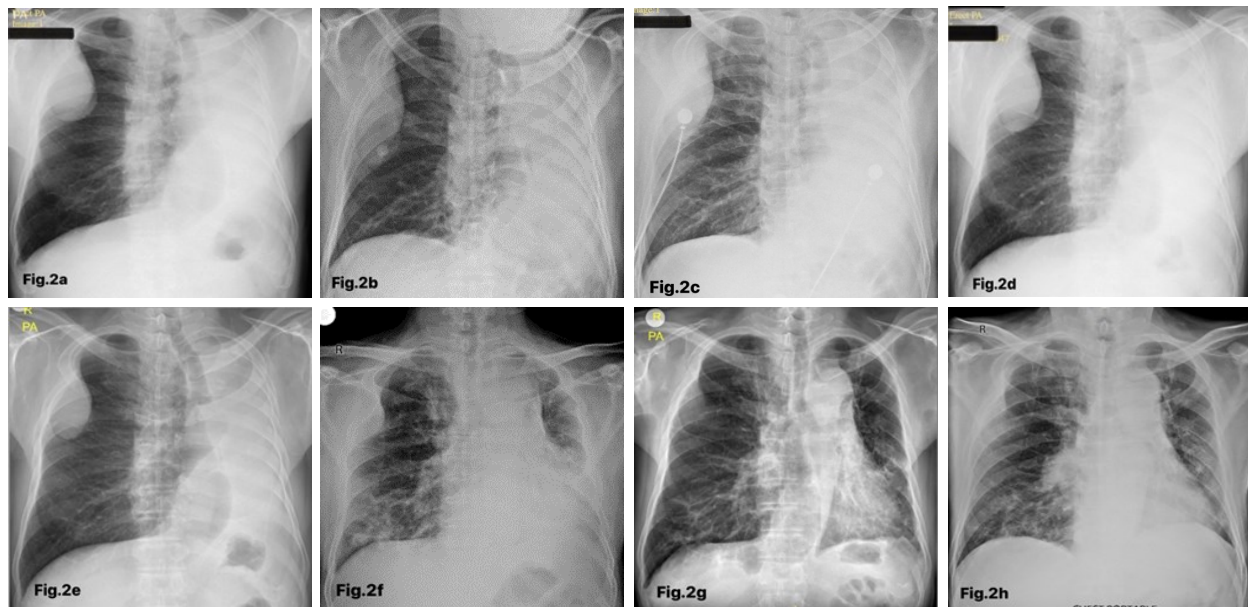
Serial chest X-rays during treatment course. 2a: Baseline chest X-ray at the time of biopsy of the right upper lobe mass showing left lung atelectasis with ipsilateral mediastinal deviation, mass-like lesion in the right upper lung with lytic changes of the 3rd rib, and compensatory hyperaeration of the right lung. 2b: Upon transfer as a case of CAO, in impending respiratory failure; no significant change noted. 2c: Post-FOB with cryotherapy; no significant change noted. 2d to 2g: During chemotherapy (four cycles of intralesional cisplatin as adjunct to systemic chemotherapy); with significant improvement in the opacity in the left lung with eventual re-expansion and an apparent decrease in the size of the right upper lobe pleural-based mass. 2h: After four cycles of intralesional cisplatin with systemic chemotherapy; re-expansion of the atelectatic left lung noted. CAO, central airway obstruction; FOB, fiberoptic bronchoscopy
